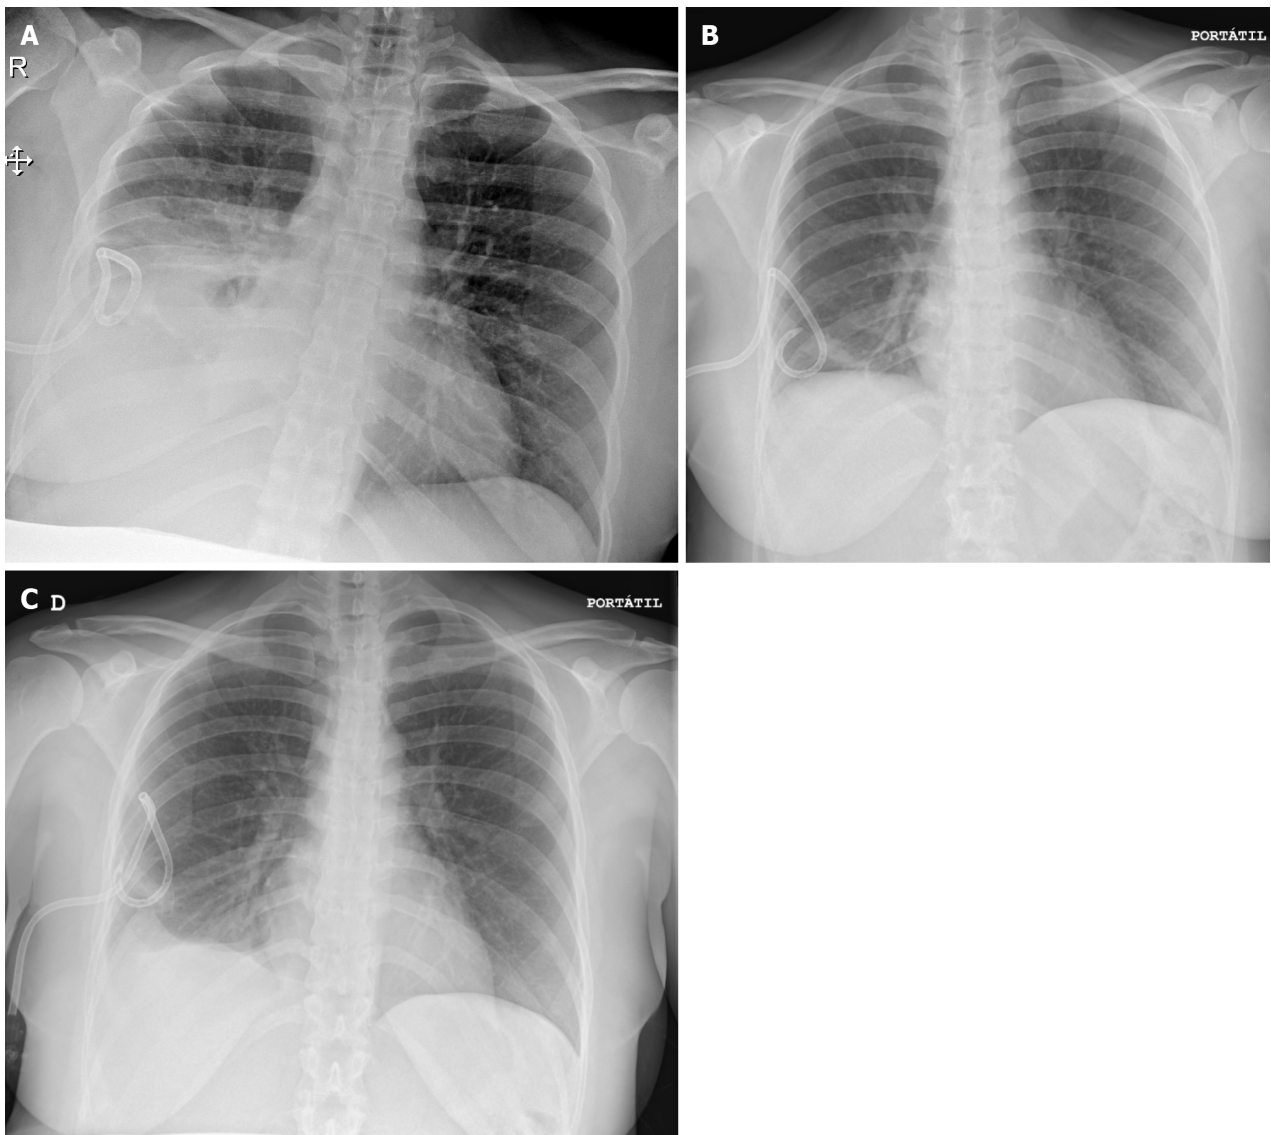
Chest X-ray. A: Chest X-ray after ultrasound-guided thoracentesis (yielding a volume of 1200 mL) and placement of the pigtail catheter for continuous pleural drainage of the right pleural effusion (November 22, 2022); B: Chest X-ray follow-up (November 23, 2022). The evolution of the patient was favorable, with periodic clamping of the drainage and treatment with furosemide and albumin; C: Chest X-ray follow-up (November 26, 2022). On this day, treatment with furosemide and albumin was discontinued. The pleural drainage was removed two days after, having drained up to 5 L during the whole hospitalization period.
